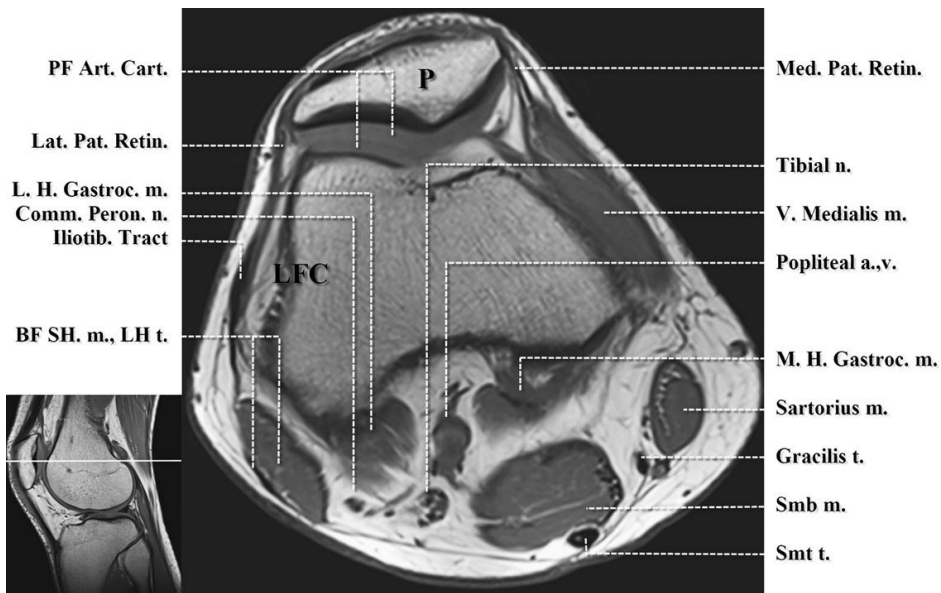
Axial T1-weighted image. Mid patellofemoral compartment. a., artery; BF SH. m., LH t., biceps femoris short head muscle, long head tendon; Comm. Peron. n., common peroneal nerve; m, muscle; n, nerve; M.H./ L.H. Gastroc., medial and lateral heads of gastrocnemius; Iliotib., iliotibial; Med./Lat. Pat. Retin., medial and lateral patellar retinacula; PF Art. Cart., patellofemoral articular cartilage; Smb, semimembranosus; Smt, semitendinosus; t., tendon; v., vein; V., vastus (*Quoted from Vohra et al., 2011*).
